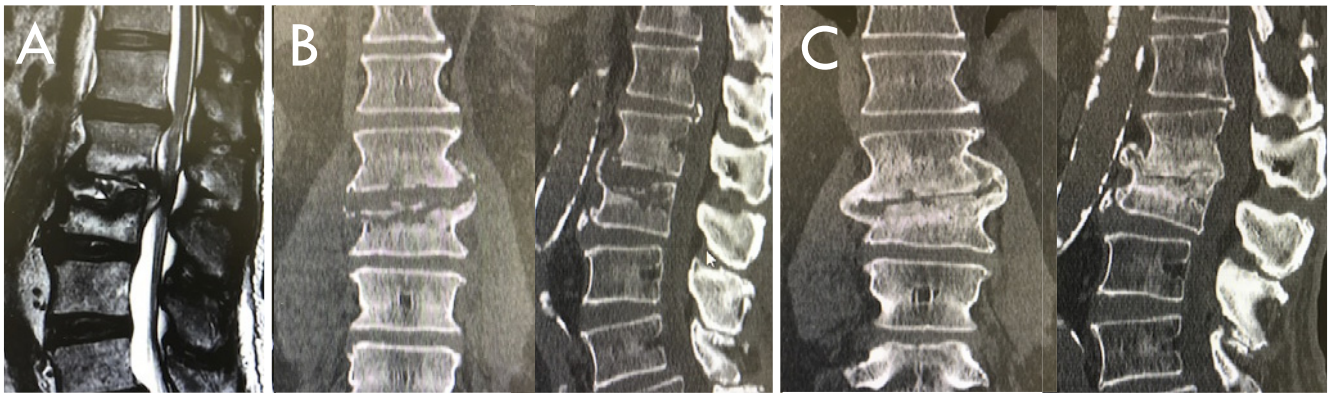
Images from a patient treated conservatively for pyogenic spondylitis (case C-1). Case C-1 is an 84-year-old man with a 3-month history of low back pain. Several days before presentation, his low back pain level increased and lower limb pain developed, making walking difficult. (A) T2WI fat suppression MRI at first consultation shows inflammation extending from the L1/2 disc to the upper and lower vertebral bodies, and an abscess extending from the intervertebral disc to the spinal canal. (B) CT at the first consultation shows bone defects in the L1 and L2 vertebral bodies and collapse of the L2 vertebral body. (C) At 1 year post-treatment, CT shows complete osteosynthesis with kyphosis.
